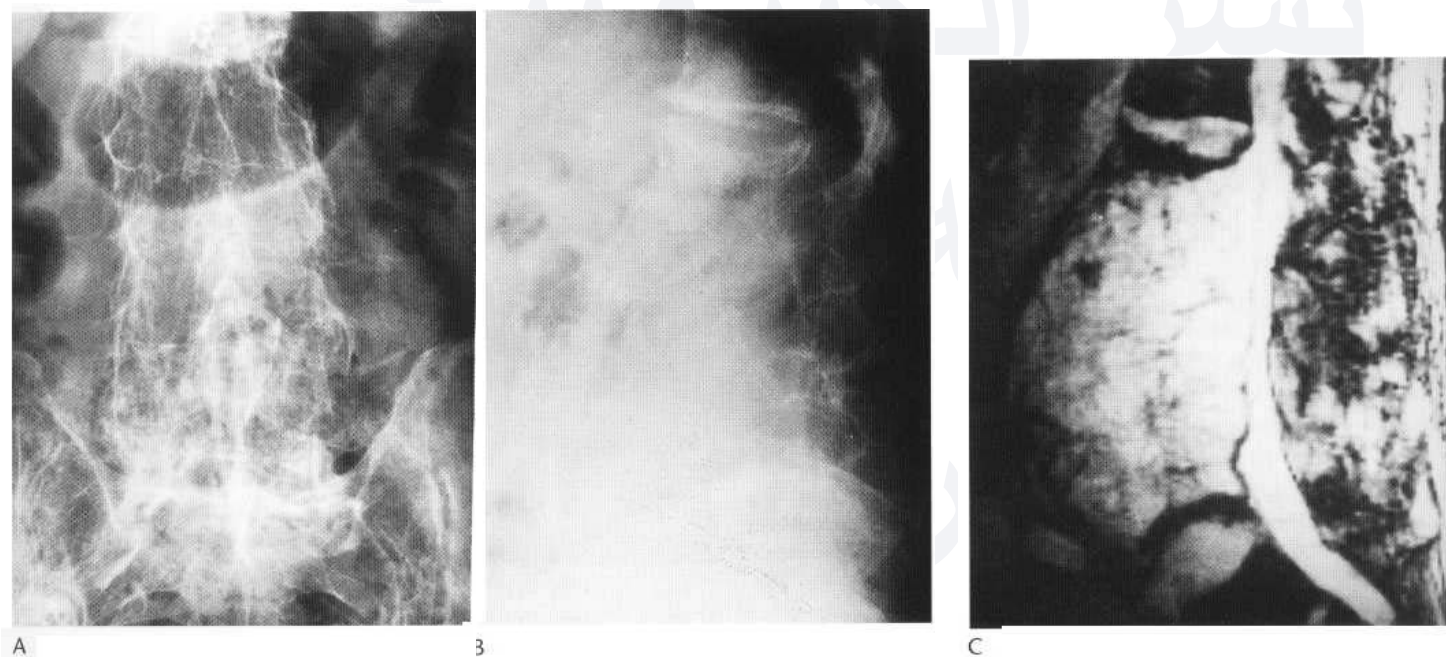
Paget's disease. (A,B) The radiographs show three expanded and apparently fused vertebral bodies in the lumbar spine, which are demineralised. The appearances are those of a highly vascular form of Paget's disease in an active phase. (C) The MR scan confirms the presence of expansion and fusion with encroachment upon the canal, and confirms the presence of vascularity.
